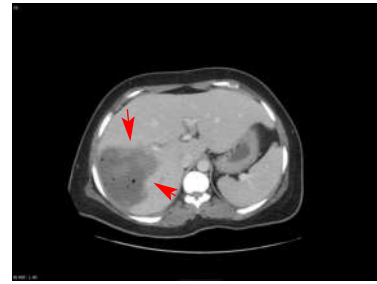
Focal nodular hyperplasia, Computed Tomography Imaging (arrows).
